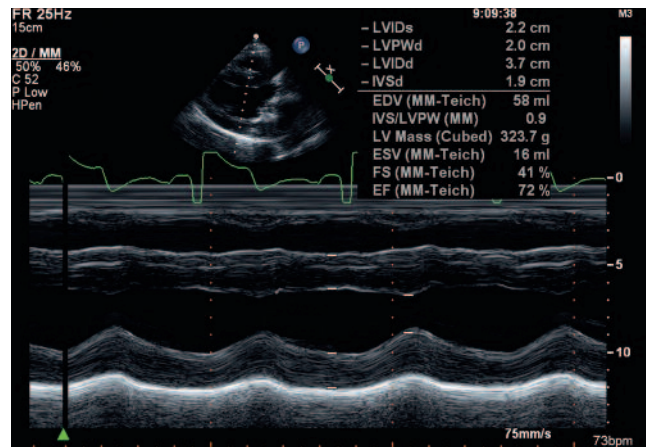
M-mode echocardiography showing left ventricular hypertrophy (wall thickness, 19 to 20 mm) and normal contraction (fractional shortening, 41%).
